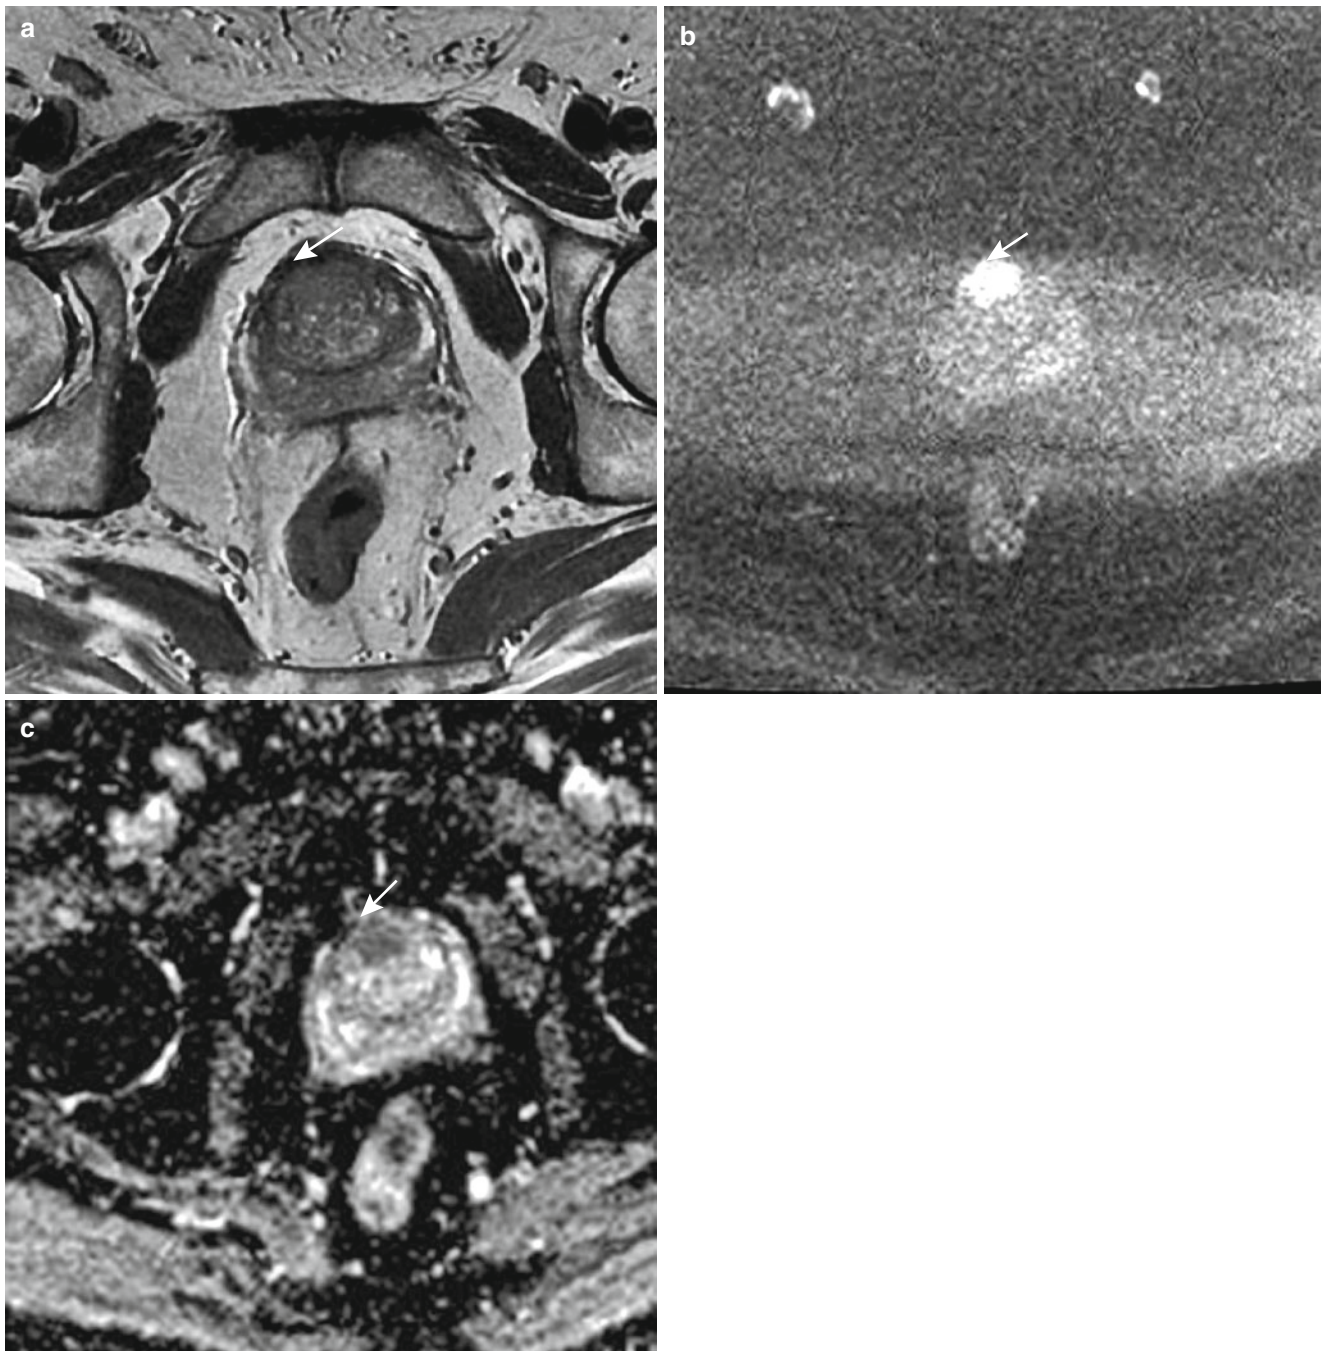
(a) A 70-year-old man presented with repeated negative TRUS biopsies but rising PSA. T2-weighted image demonstrates low signal changes in the bilateral peripheral glands which are negative on TRUS biopsy. (b) DWI demonstrates a small area of focal high signal
